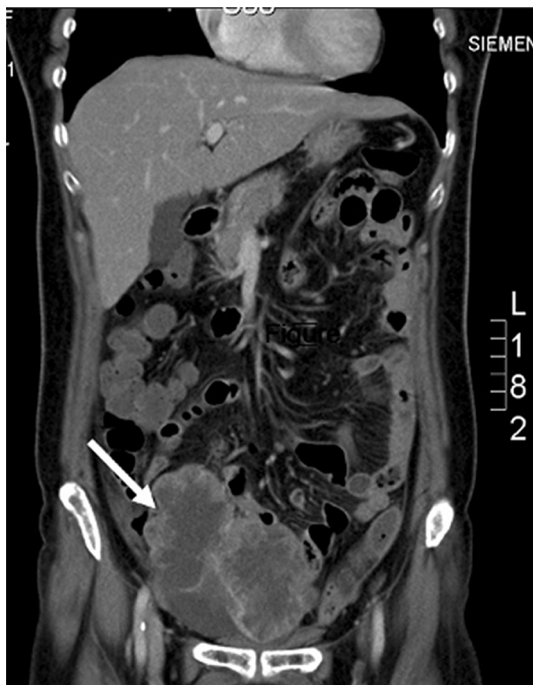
Computed tomographic scan showed one 10-cm hypervascular, heterogeneous mass (arrow) in the right lower pelvic cavity.
